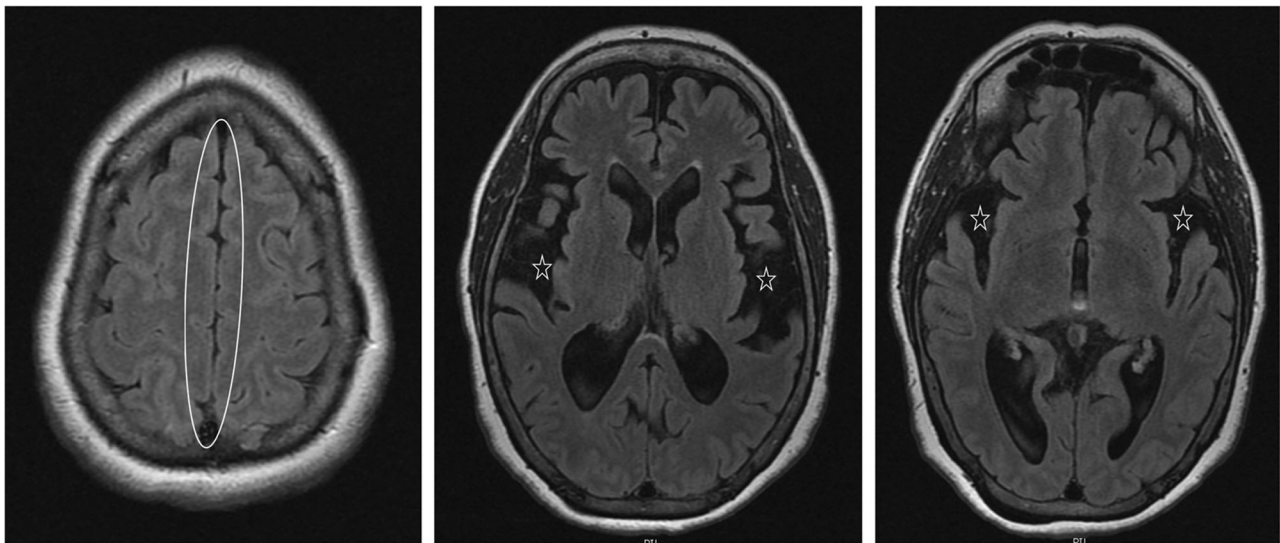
Axial T2 FLAIR MRI images of an iNPH patient demonstrating minimal sulcal spaces at the vertex (circled) despite disproportionately enlarged subarachnoid spaces in the lower sequences (star) consistent with a DESH pattern of hydrocephalus. Reproduced from Williams and Relkin [6] with permission.
